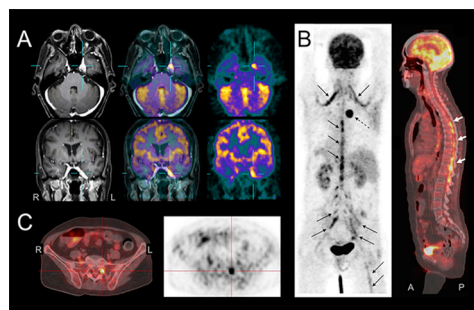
¹⁸F-FDG PET/CT/MRI fusion showed thickening and infiltration in 75% of peripheral nerves and enlargements of cranial nerves in the parasellar region of the skull with marked hypermetabolism in the left trigeminal ganglia (A), possibly related to lymphomatous infiltration. ¹⁸F-FDG PET/CT showing widespread active involvement of the cervical plexus, bilateral peripheral nerves, and Right femoral nerve (B) with a conspicuous lymphomatous infiltration through the lateral foramina in the lumbar spine (C). (R, Right; L, left; A, anterior; P, posterior)
